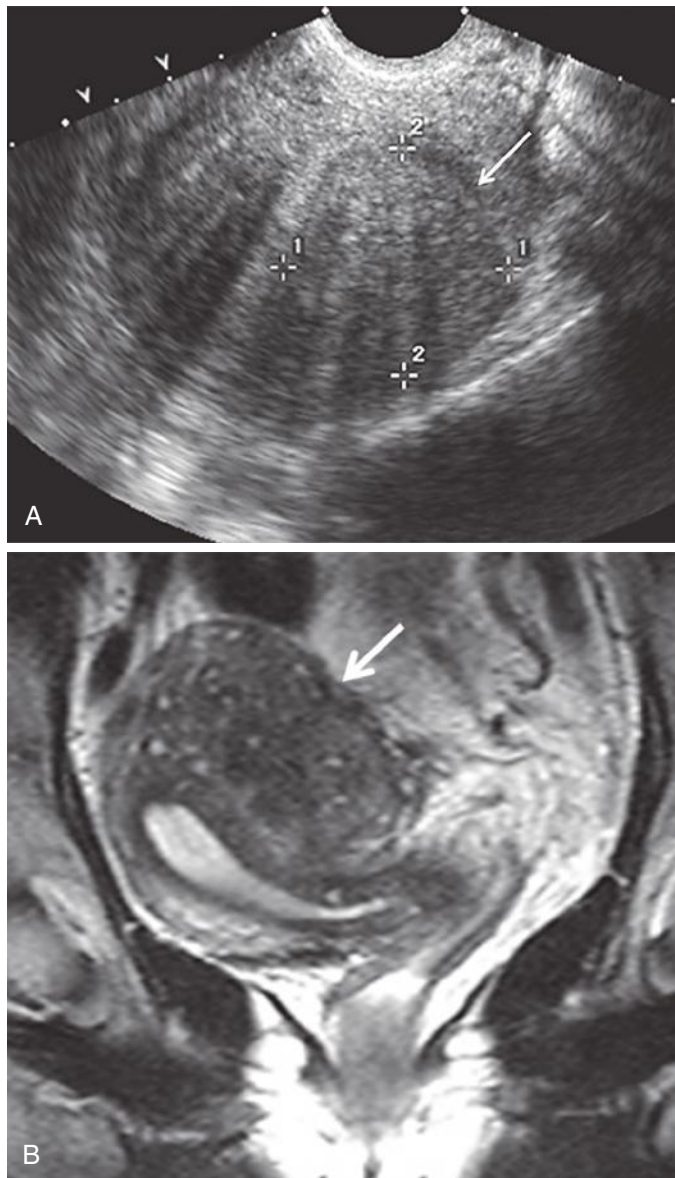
Focal adenomyosis mimicking leiomyoma. A, Transvaginal sonogram suggests an ill-defined hypoechoic lesion in the posterior myometrium (*arrow* and *calipers*) without associated mass effect. Note “comb-like” shadowing posterior to this area as well as in the adjacent myometrium, which can be seen with adenomyosis as well as leiomyomas. B, Sagittal T2-weighted magnetic resonance image reveals focal adenomyosis (*arrow*) posteriorly. No myoma present.
